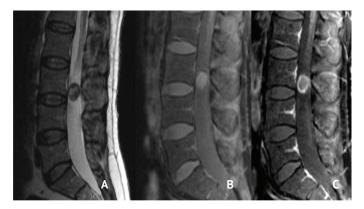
Intradural paraganglioma at L3-L4 level, MRI sections A) T2-weighted MRI, sagittal section, B) T1-weighted MRI, sagittal section after IV contrast injection
